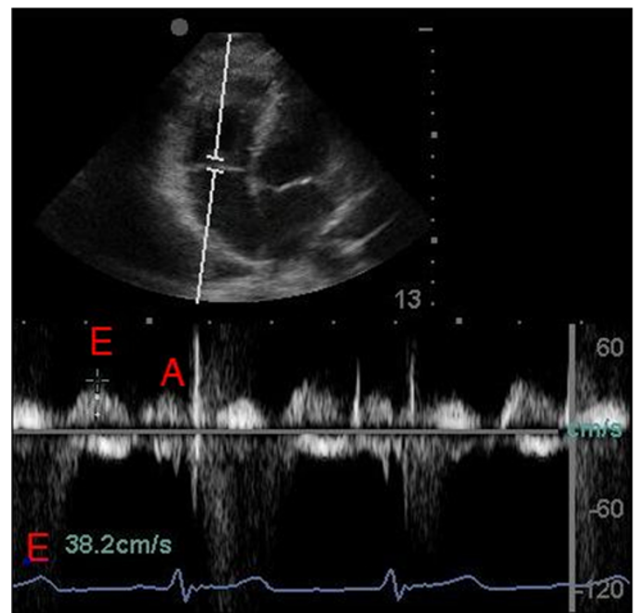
Apical 4 chamber view: tricuspid pulse doppler early diastolic E wave
